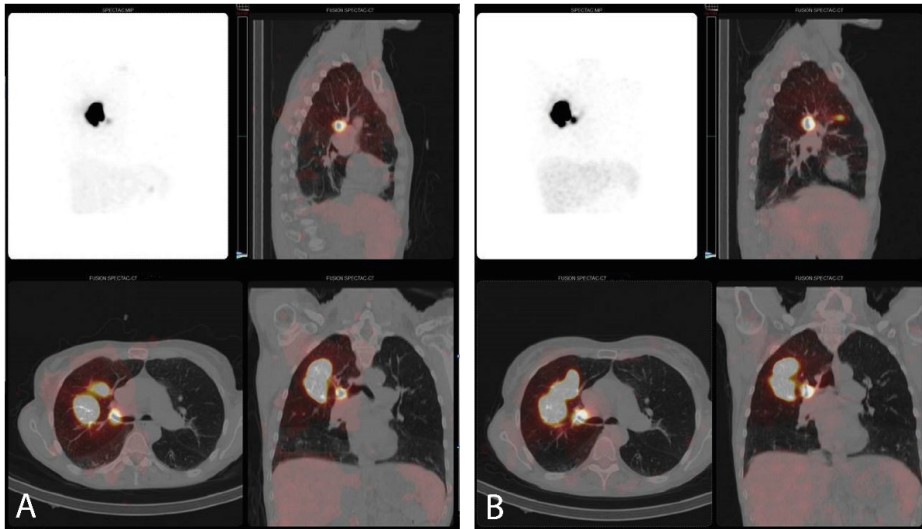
Visualization of the ^{99m}Tc -nanocolloid detection in the coronal plane (upper left) and combined SPECT and low-dose CT images in the sagittal (upper right), transversal (lower left) and coronal plane (lower right) in one patient with an early scan time of 02:09 h (A) and a late scan time of 04:09 h (B). The SLN is visible in both scans, although more of the ^{99m}Tc -nanocolloid seems to have drained to the lymph node in the late scan. CT, computed tomography; SLN, sentinel lymph node; SPECT, single photon emission computed tomography
